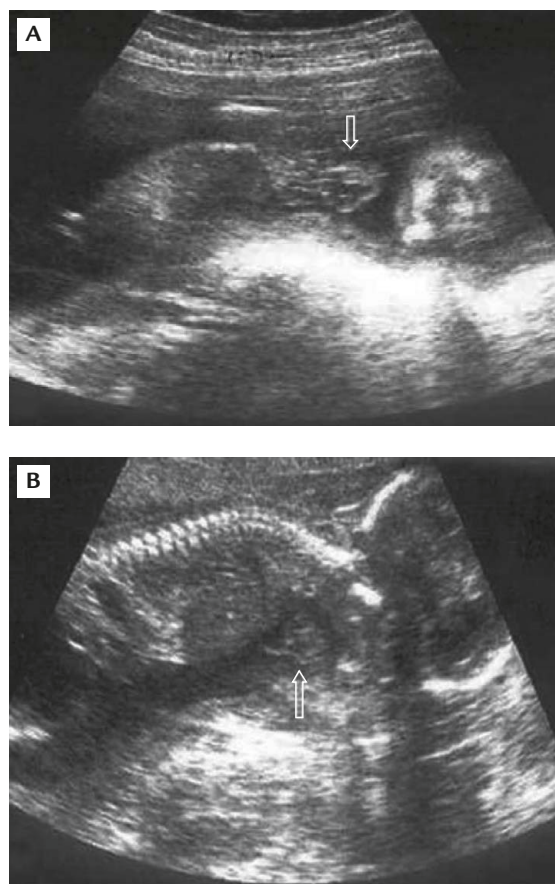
(A, B) Transabdominal sagittal sonogram shows the fetal heart in its pericardial sac, lying completely outside the chest cavity (arrow).
